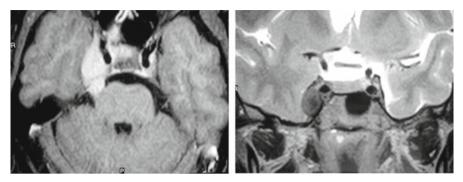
TIW CE and T2W MRI images in a case of parasellar fungal granuloma
